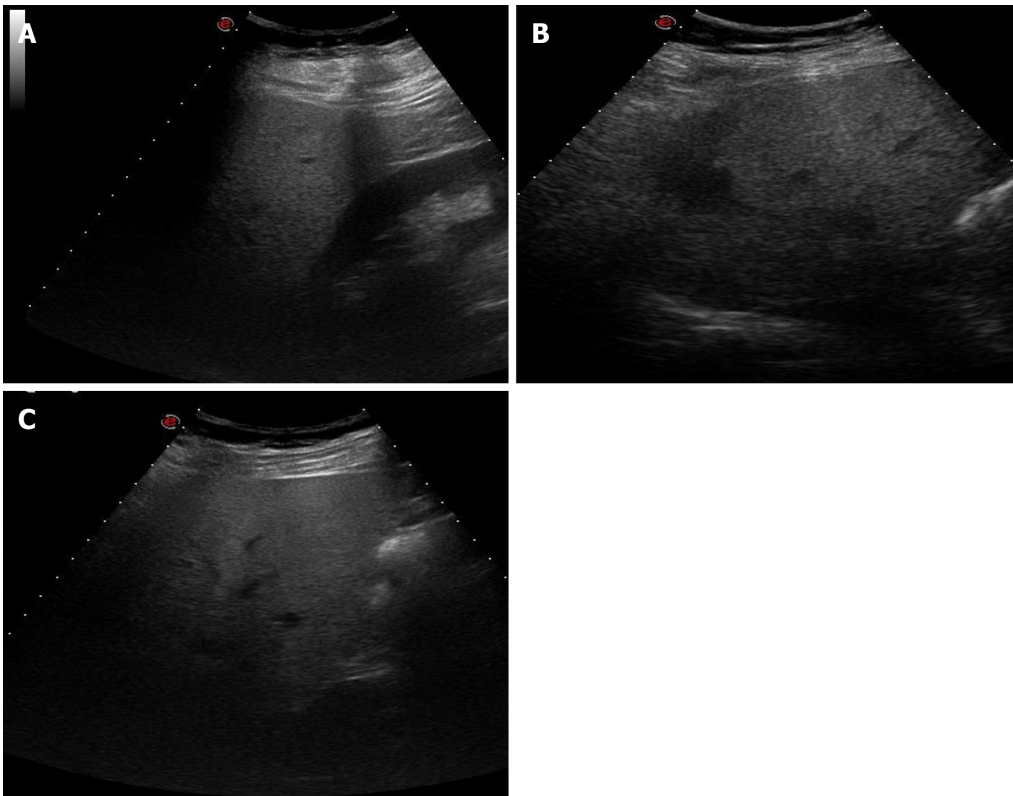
A 38-year-old man with abdominal discomfort. A: Abdominal ultrasound image demonstrated hepatic steatosis as an increase in echogenicity compared to the renal cortex; B: Abdominal ultrasound image demonstrated hepatic steatosis as loss of physiological hyperechogenicity of the wall of the portal branches; C: Abdominal ultrasound image demonstrated hepatic steatosis as posterior attenuation of the ultrasonic beam with failure to visualize the diaphragm.
